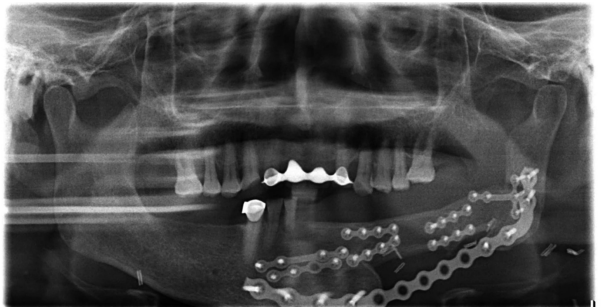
Postoperative panoramic radiograph showing fibular bone fixed above R-plate.
